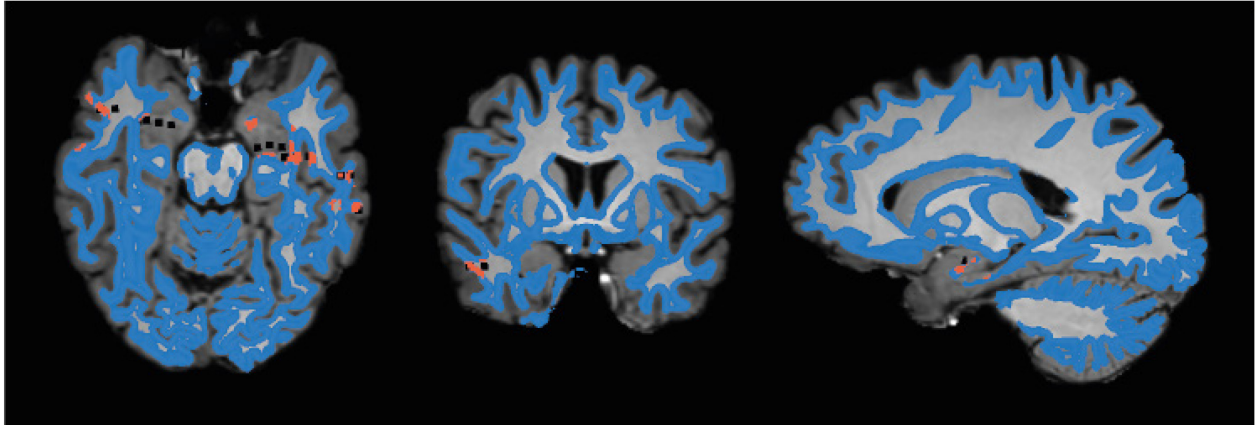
Electrode contact areas (orange) and the electrode contact coordinates (black) are displayed as an overlay on the MRI-DWI with the segmented grey-white matter boundary visualized in blue. We see that the electrode contact areas are located near the real electrode contact coordinates.
